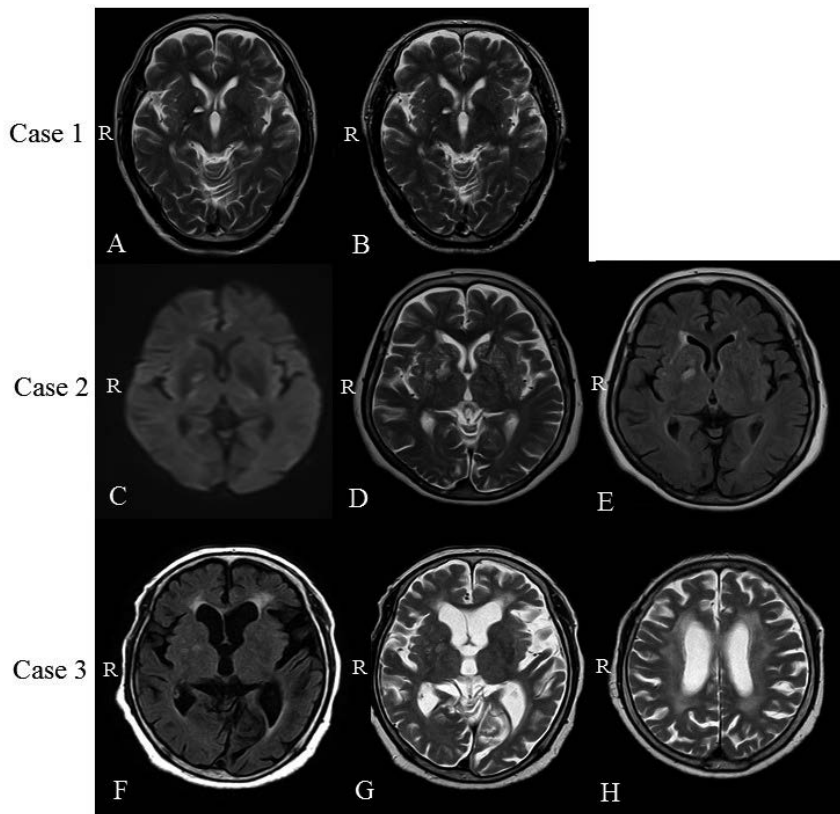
Magnetic resonance image findings for the three hemichorea-hemiballism cases. In case 1, brain magnetic resonance image (MRI) shows the old cerebral infarct in the right globus pallidus present for the past four years (A: T2 weighted MRI image (T2WI) at the onset, B: T2WI at the four years before the onset). In case 2, MRI shows the subacute cerebral infarcts in the right globus pallidus (C; Diffusion weighted image (DWI), D; T2WI, and E; Fluid attenuated inversion recovery (FLAIR)). In case 3, MRI shows periventricular hyperdensity (PVH), old infarcts in right globus pallidus and putamen (F; FLAIR, G; T2WI, and H; T2WI).
